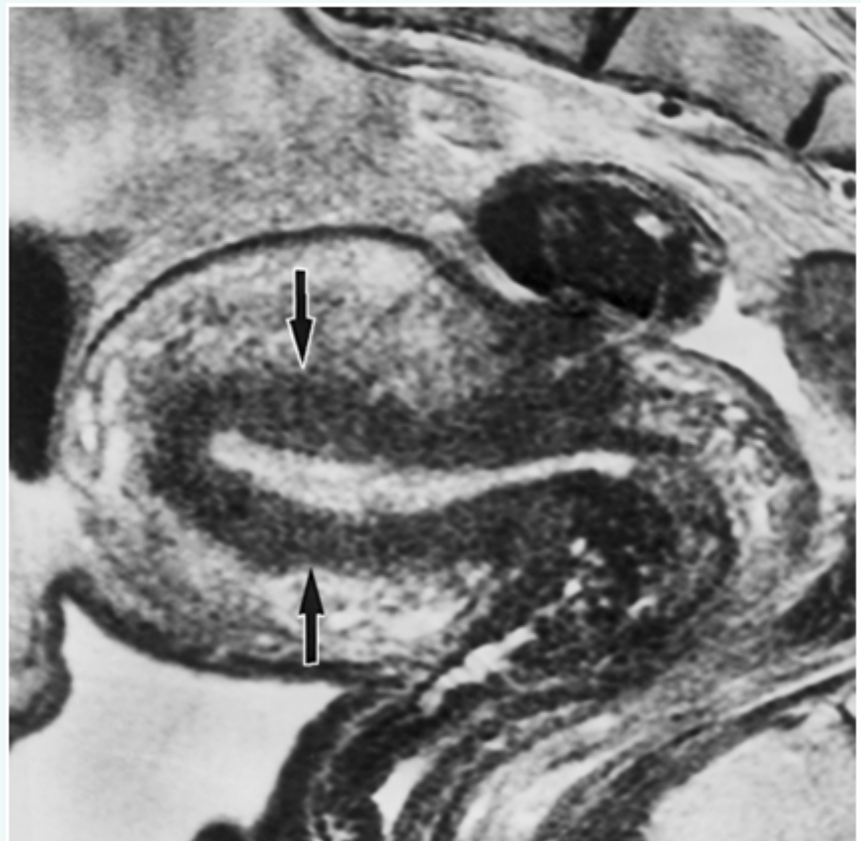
mild diffuse adenomyosis demonstrates mild thickening of the junctional zone (arrows). From RadioGraphics, 19, S161-S170.
